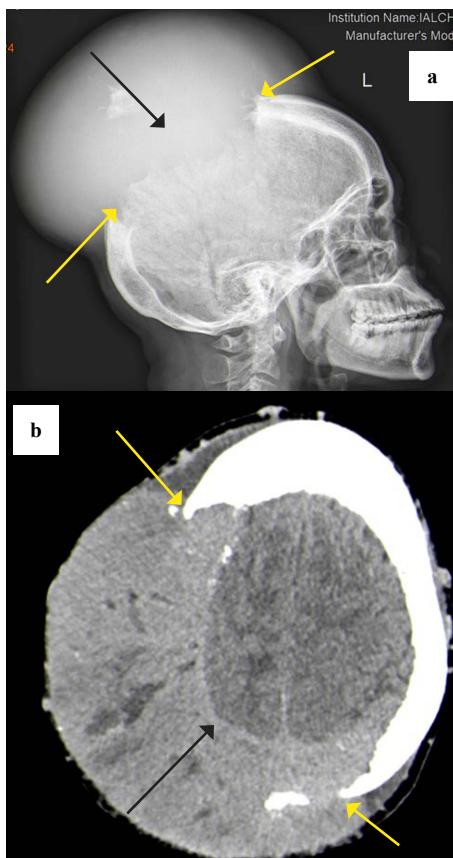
A - Skull X-ray. B - CT scan (axial view)
